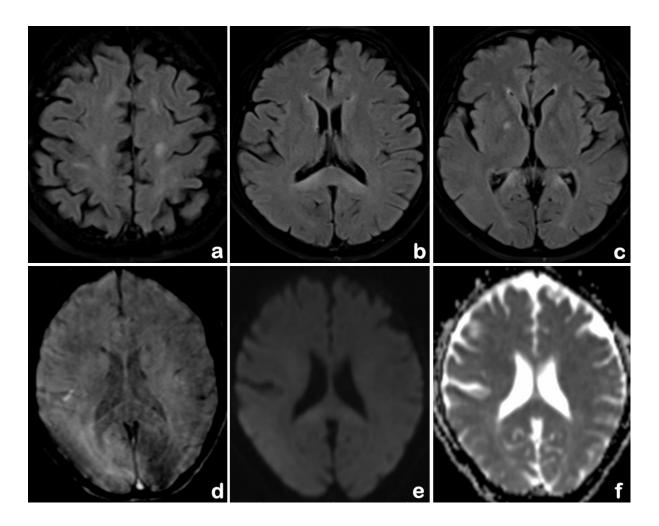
Axial FLAIR images (a-c) show ill-defined, patchy asymmetric hyperintensities involving the subcortical white matter of the frontal lobes (a) and corpus callosum splenium (b). Discrete hyperintense foci are seen in the anterior part of the Globus pallidi (c). Few microbleeds are noted in the corpus callosum splenium on the axial SWI image (d). Note that the diffusion restriction across the corpus callosum on the diffusion weighted trace image (e) and ADC map (f) is not as striking as in subsequent figure 3. The white matter changes are patchy and asymmetric unlike figure 3. This was a mild case of High-altitude cerebral edema where the patient recovered without any sequelae.
